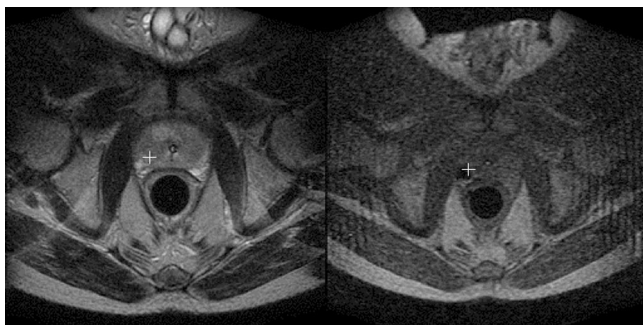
Representative MR images from a clinical study (64 years old; PSA = 18.0 ng/dL; prostate volume = 67.6 cc). A preprocedural T2-w image with the target (white cross mark) (left) and intraprocedural coherent gradient echo image from the same study targeting the same target (white cross mark) (right). The needle artifact in the coherent gradient echo images indicates needle location.
